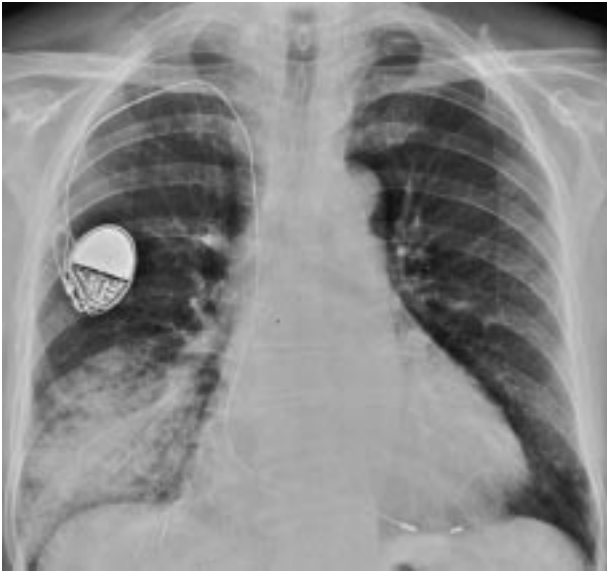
Chest radiograph showing alveolar consolidation in the right lower lung field.
